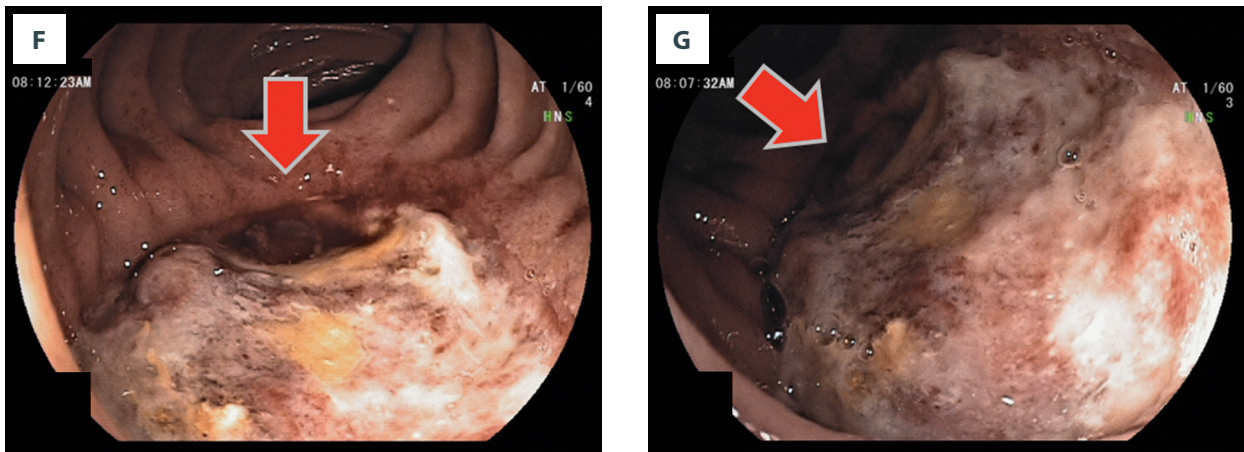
(A-C) 3D vascular reconstructions of Computed Tomography. A, B – Arterial phase. C – Venous phase. The marks show the localization of pancreatic graft. It is not visible because of the absence of blood flow. (D-G) Images from gastroduodenoscopy. Marks show the necrosis of the mucosa of transplanted duodenum with central ulceration.
